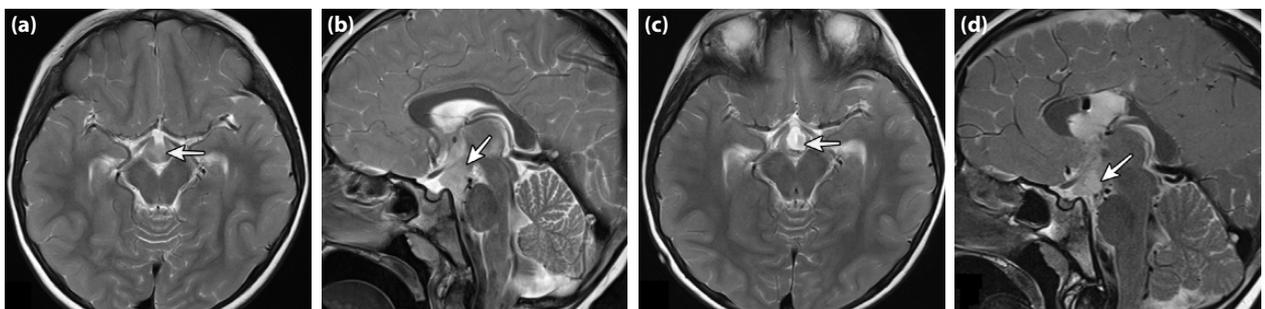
(a) Axial section T2 weighted MRI of a patient with type 3 HH (arrow). (b) Sagittal section T2 weighted MRI of the same patient (arrow). (c) Axial section T2 weighted MRI of the patient after disconnection surgery through the interhemispheric route. Arrow designates disconnection plane. (d) Sagittal section T2 weighted MRI of the same patient after disconnection surgery. Arrow designates the disconnection plane.
